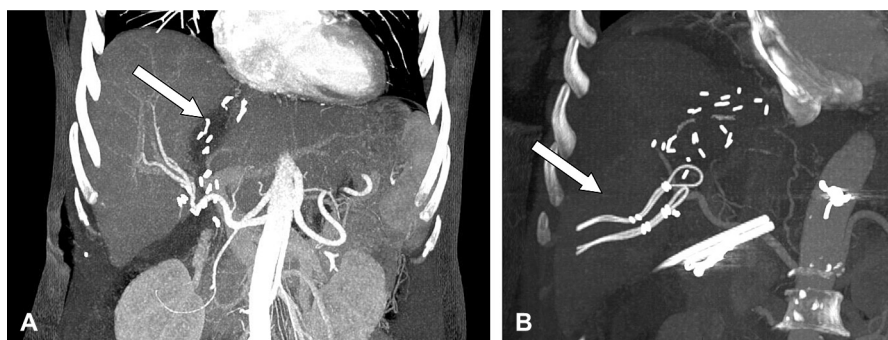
Postoperative day 7 CT scan reconstructions. (A) The liver transection line and the disconnection of the right portal vein are clearly seen (white arrow). (B) Silastic vessel loops and clips along the liver transection line (white arrow).
